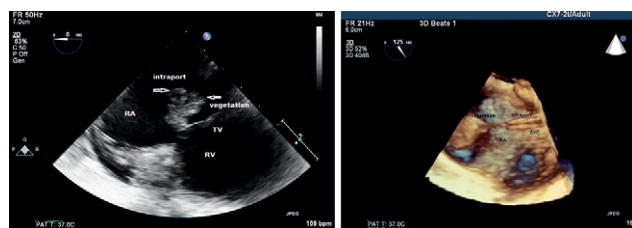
Transesophageal echocardiogram. RA, right atrium; RV, right ventricle; TV, tricuspid valve; SVC, superior vena cava.
